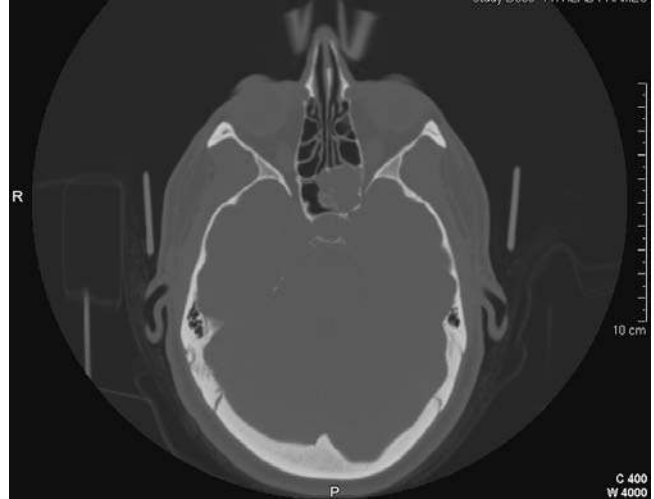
CT scan of a chondromyxoid fibroma involving the posterior nasal cavity and anterior sphenoid sinus. The radiologic differential diagnosis included inverted papilloma, lymphoma, and chondroid neoplasms.
